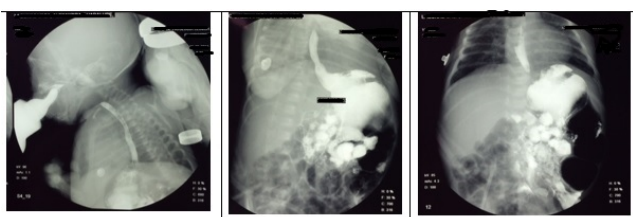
Esophagus-gastro duodenal series in which a normal swallowing mechanism, without passage of the contrast medium into the airways, with normal traffic in oral and pharyngeal phase is observed. The esophagus is normal in position, peristalsis and contours. No movement or presence of leakage of contrast into other structures is observed. No signs of hiatal hernia. Gastric emptying is apparently normal. The angle of Hiss is open, which probably favors a reflux, the mucosal contours of the stomach and duodenum is normal. No areas of blockage in pylorus or duodenum are identified. The location of the duodenal jejunal angle is normal and there is no data to suggest poor intestinal rotation. The study was performed under fluoroscopic and static X-rays
